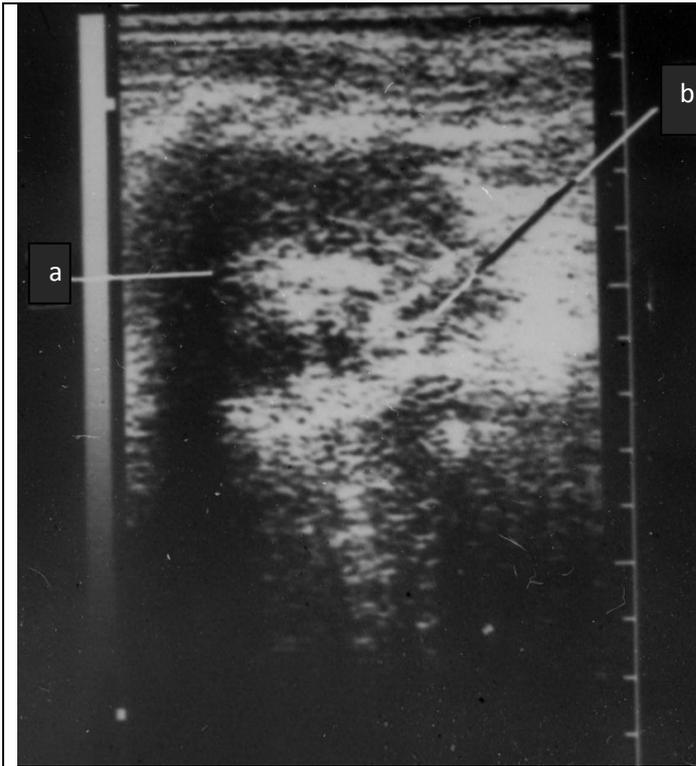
Sonogram of kidney.
